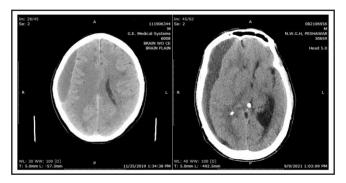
CT of Right-Sided Hematoma (scan included with patient's permission).
